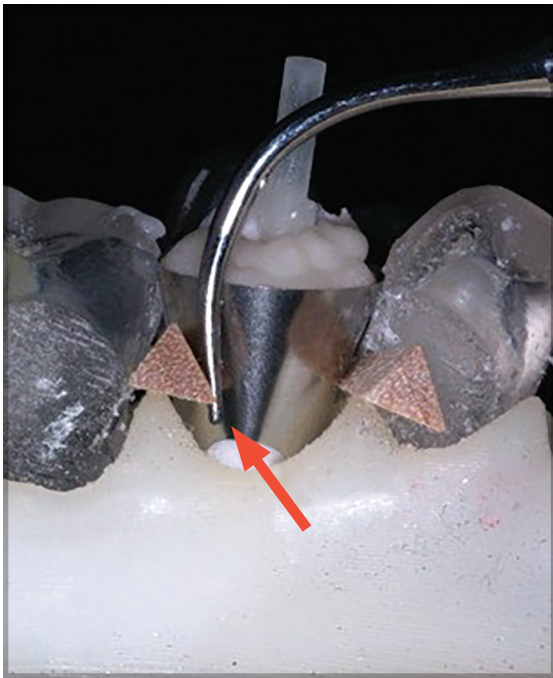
Restorative setup augmented with the ultrasonic tip (arrow) applying 5 seconds of vibration to the outside of the lingual aspect of the matrix band.
